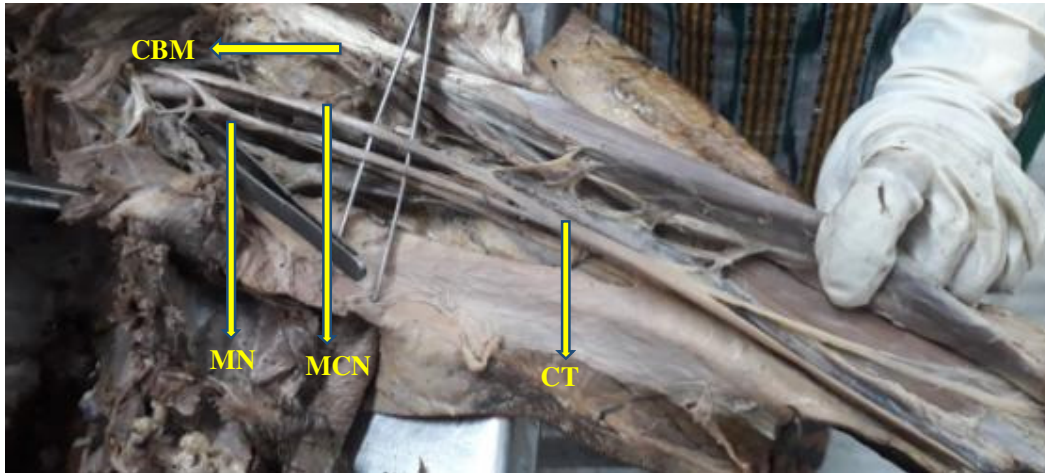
showing complete fusion of MCN (musculocutaneous nerve) with MN (median nerve) thus forming a CT (common trunk), CBM: coracobrachialis muscle.
